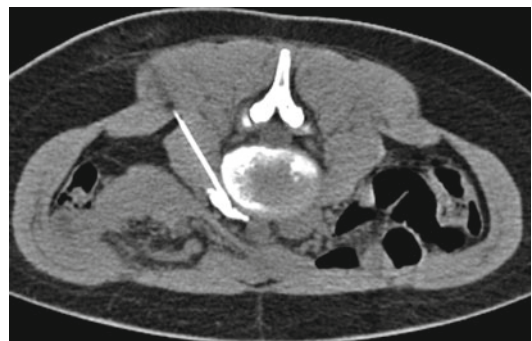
A 16-year-old girl suffering from reflex sympathetic dystrophy of the left foot. For CT-guided (100 kVp, 50 mA s_{eff}) left lumbar sympathicolysis 15-ml bupivacaine mixed with 0.5 ml contrast material for visualization of the fluid distribution was injected paraaortally at the level of lumbar vertebra 3. Immediately after the injection, the patient described a warm feeling in the foot, and the perfusion improved as could be seen by the change of the skin color of the foot. The procedure was repeated six times until the problems resolved permanently
